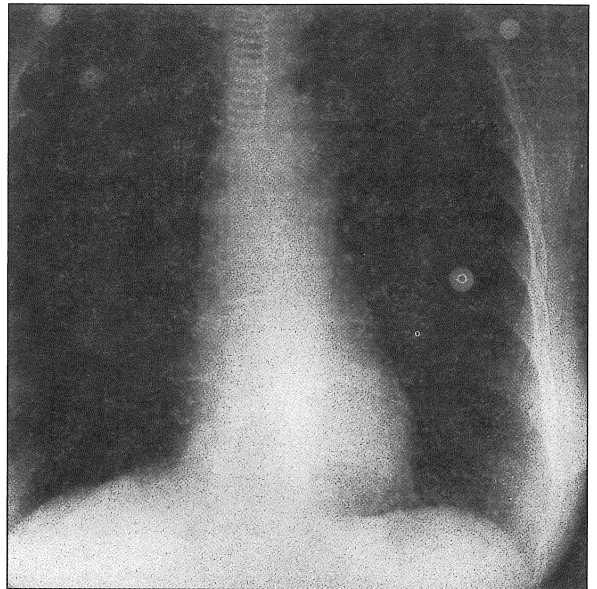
Chest radiograph showing dynamic stent in the trachea and both main bronchi
